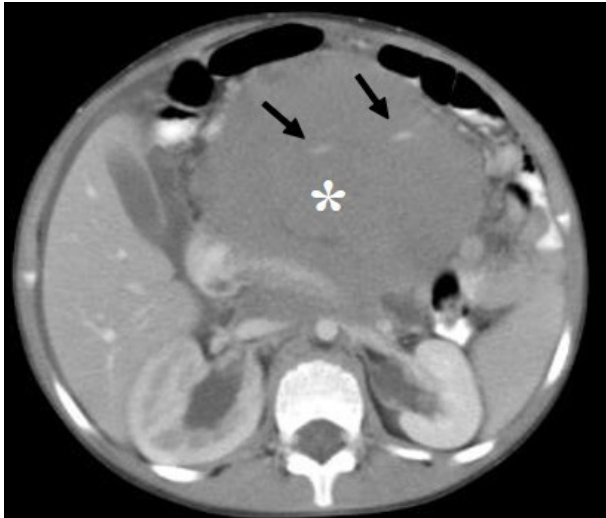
Repeat CT scan at the same level as in Fig. 1. There is a large solid mesenteric mass (*) displacing the bowel loops and completely encasing the mesenteric vessels (arrows).
